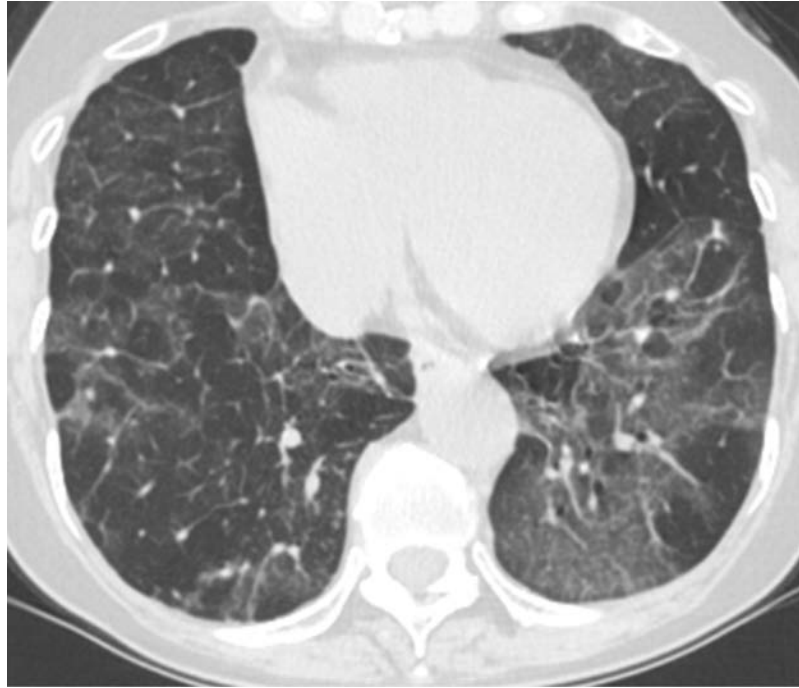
Chest computed tomography showing diffuse ground-glass opacities along with thickened interlobular septa, consistent with crazy-paving appearance.
